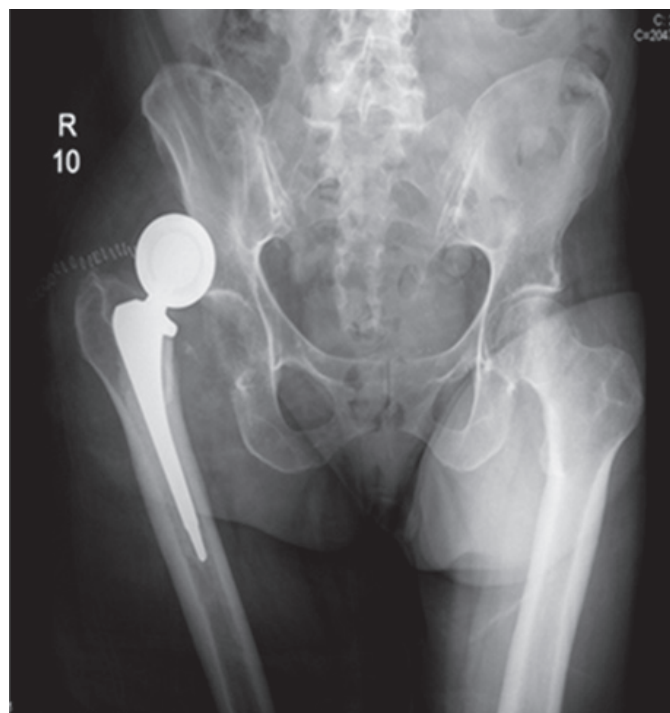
Radiograph of initial right prosthetic hip dislocation.
